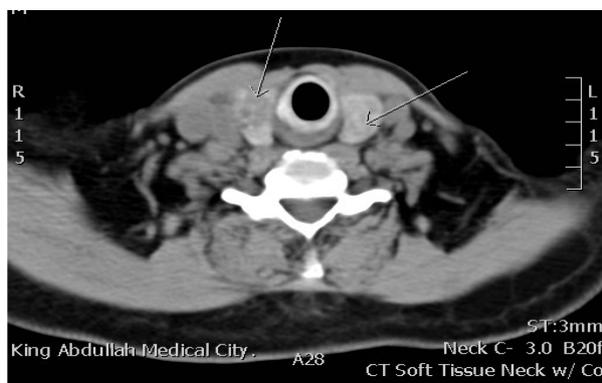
Axial CT neck; bilateral thyroid soft tissue nodules.
